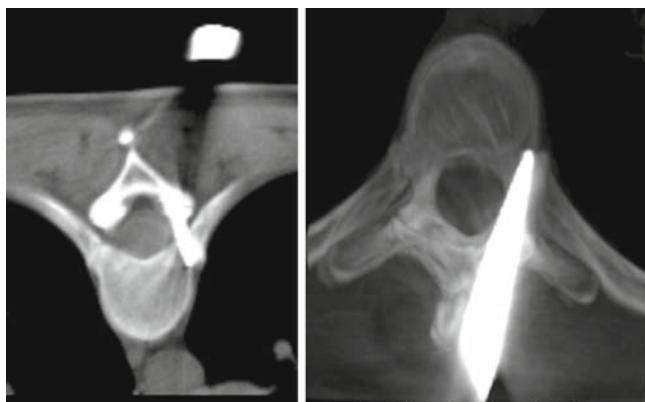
Computed tomography scan reveals close proximity of the scissor blade to the spinal cord
